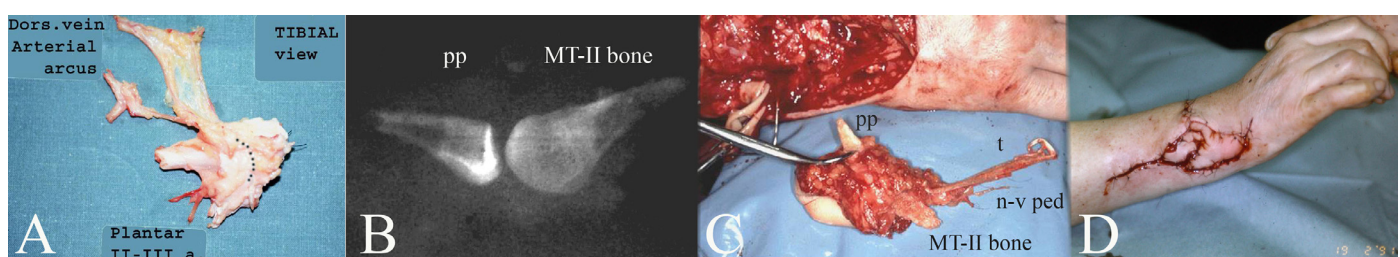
(a) An MTP-II joint graft without skin showing necessary vascular elements. Observe the broad fat layer between the dorsal vein branches for initial coverage. (b, d, c) First clinical case 1991. (b) X-ray demonstrating the bones and the joint in the graft. (MT-II bone = Metatarsal part of the graft. pp = proximal phalanx part of the graft). (c) The free prepared joint graft at operation (MT-II bone = Metatarsal part of the graft. pp = proximal phalanx part of the graft, n-v ped = neurovascular pedicle including two arteries, vein and two dorsal nerves, t = tendons). (d) monitoring skin island with a good circulation at the end of operation.
